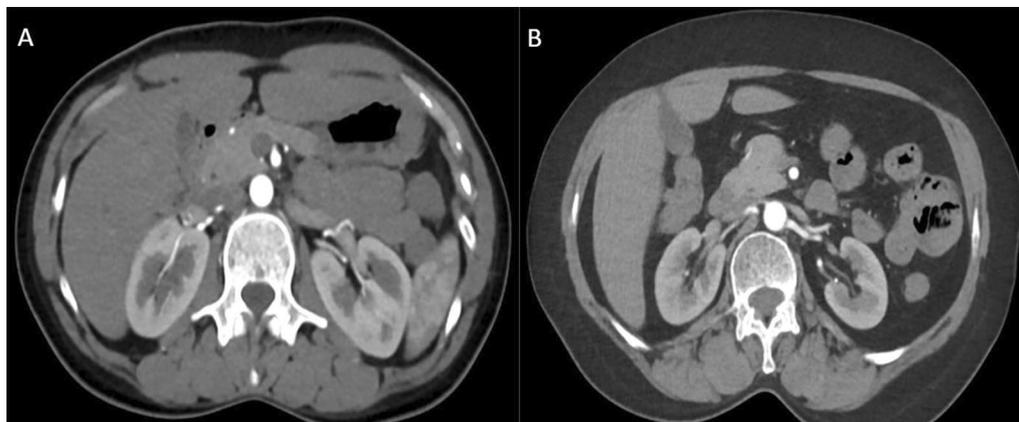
Contrast CT Axial images of DECT (A) and Turbo Flash (B) at the renal artery level shows comparable image quality between both
